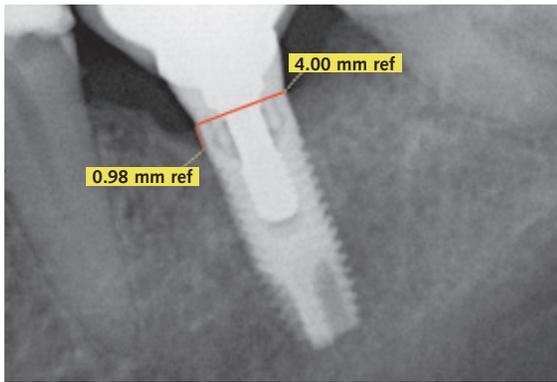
Peri-implant marginal bone level measurements were made directly on the standardised digital periapical radiographs using Sidexis XG software. Measurements were calibrated with the known implant diameter (4 mm) to the nearest 0.01 mm.
